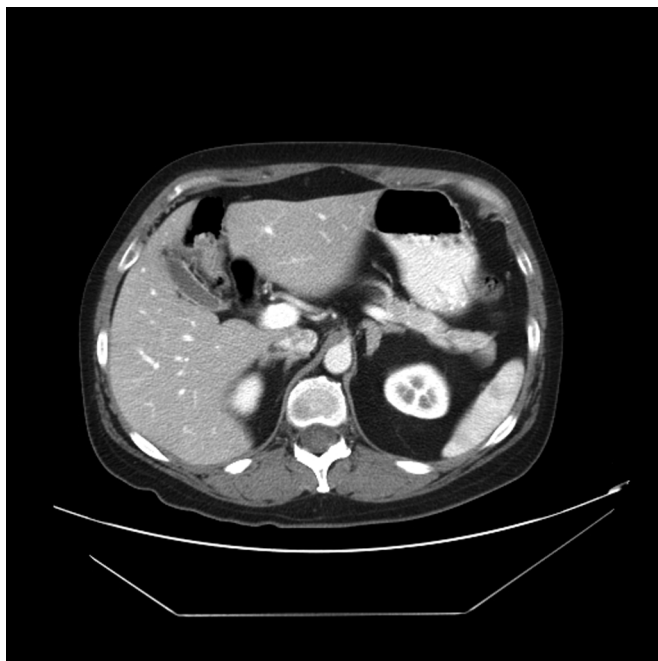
Computed tomographic scan of abdomen with contrast revealing bilateral adrenal hyperplasia. No masses or nodules seen.
